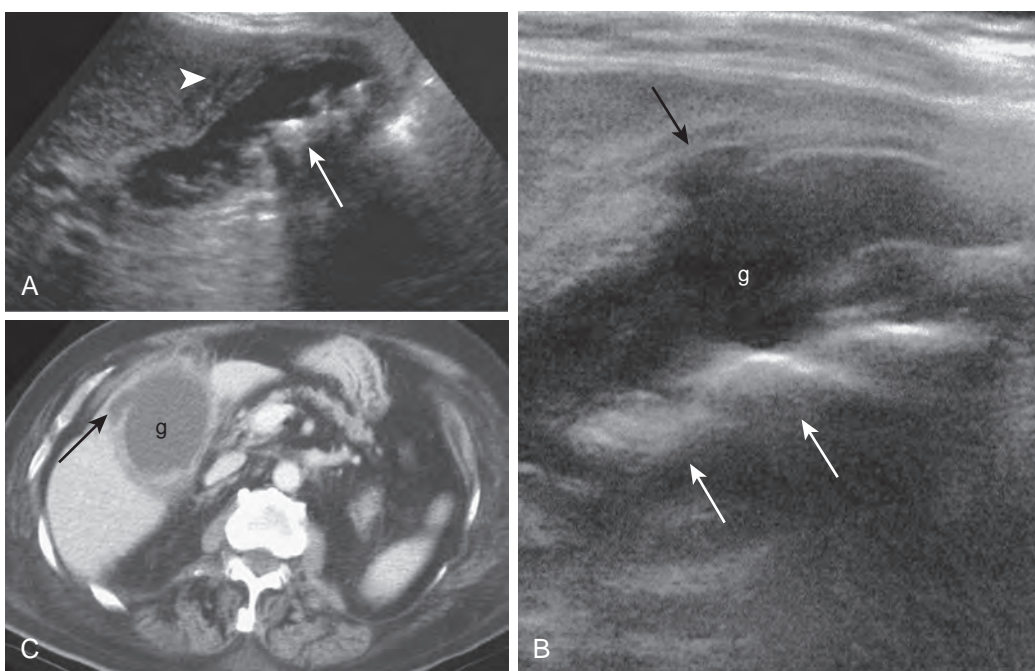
Gallbladder perforation. A. Sagittal scan shows mural thickening with striations (arrowhead). Arrow, Multiple gallstones. B. Sagittal scan obtained with a linear transducer (8 MHz) produces higher resolution image. Focal defect in gallbladder wall (black arrow) is now evident. This indicates a focal intramural abscess or contained perforation. White arrows, Gallstones. C. Contrast-enhanced CT confirms focal defect (arrow) in gallbladder (g) wall. Mural thickening and pericholecystic inflammatory changes are present, consistent with acute cholecystitis.
